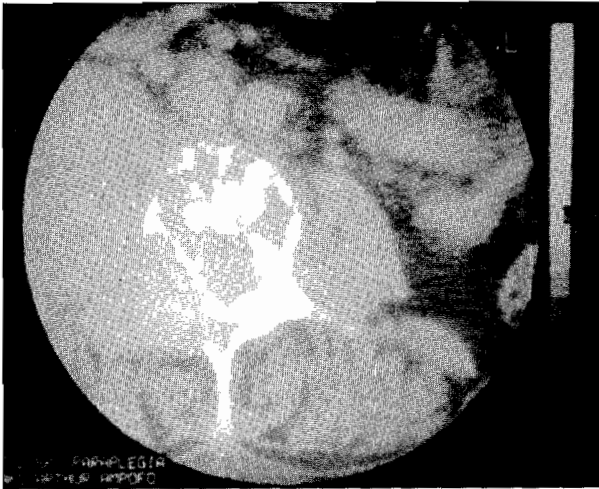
Contrast enhanced axial CT image of the intervertebral disc showing irregular osteolytic destruction. Associated right paraspinal and extradural soft tissue masses are also present.
